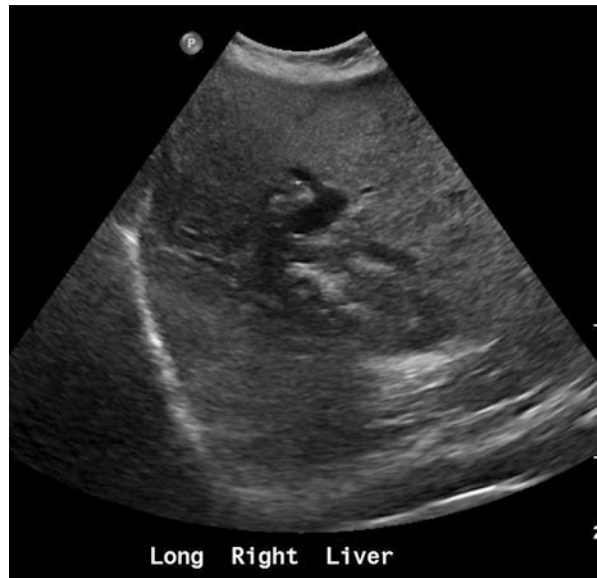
Ultrasound demonstrating stones within the biliary tree after transplant
